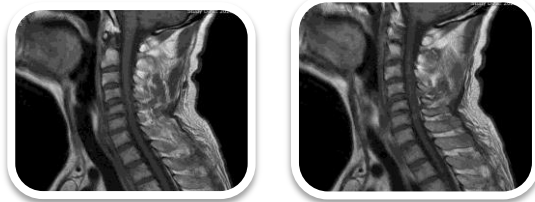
Sagittal view of cervical magnetic resonance imaging (MRI) 6 weeks after initial trauma showing grade 1 C5 posterolisthesis on C6
